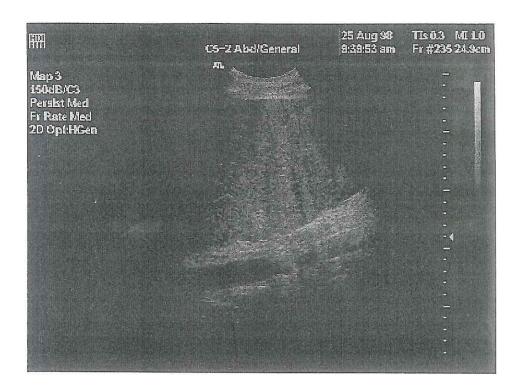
SAE in the late phase of Levovist. A small echogenic lesion can just be discerned in the control image (upper panel); it is much more clearly seen when colour Doppler is switched on to elicit stimulated acoustic emission (lower panel).
